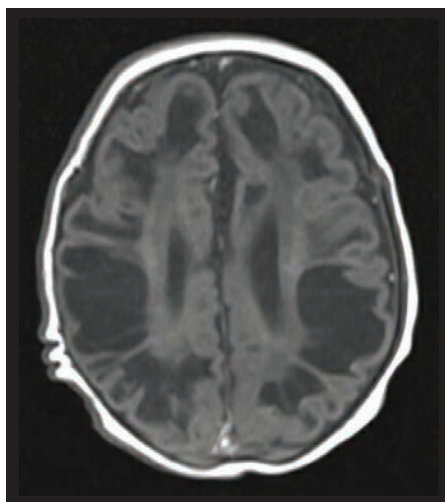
Axial T1 MR image showing extensive cystic changes throughout the brain parenchyma.
